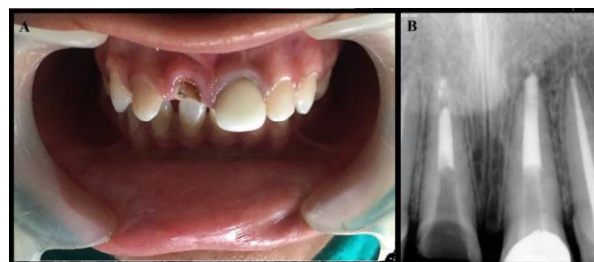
Pre - operative photograph of the maxillary right central incisor. B. Preoperative diagnostic radiograph showing MTA placed 2 mm short of apex.
